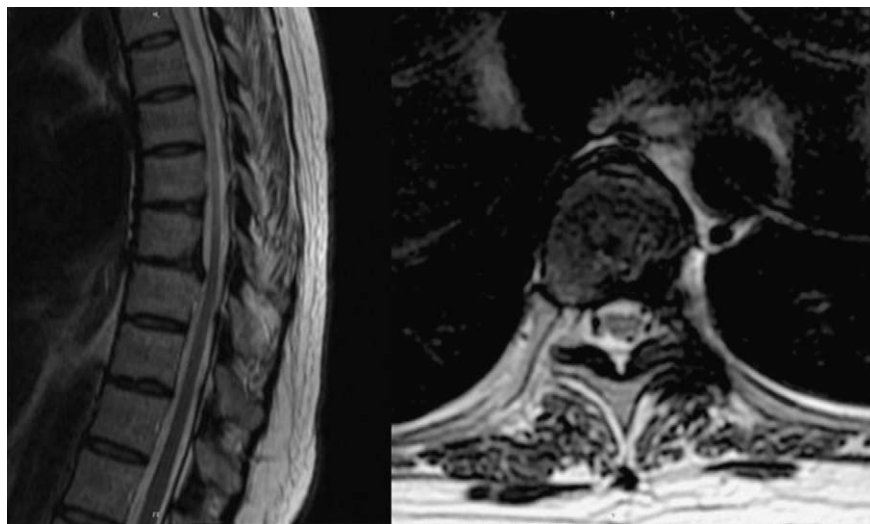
Postoperative sagittal (*left*) and axial (*right*) MR image showing good neural decompression after surgery with post operative changes.
